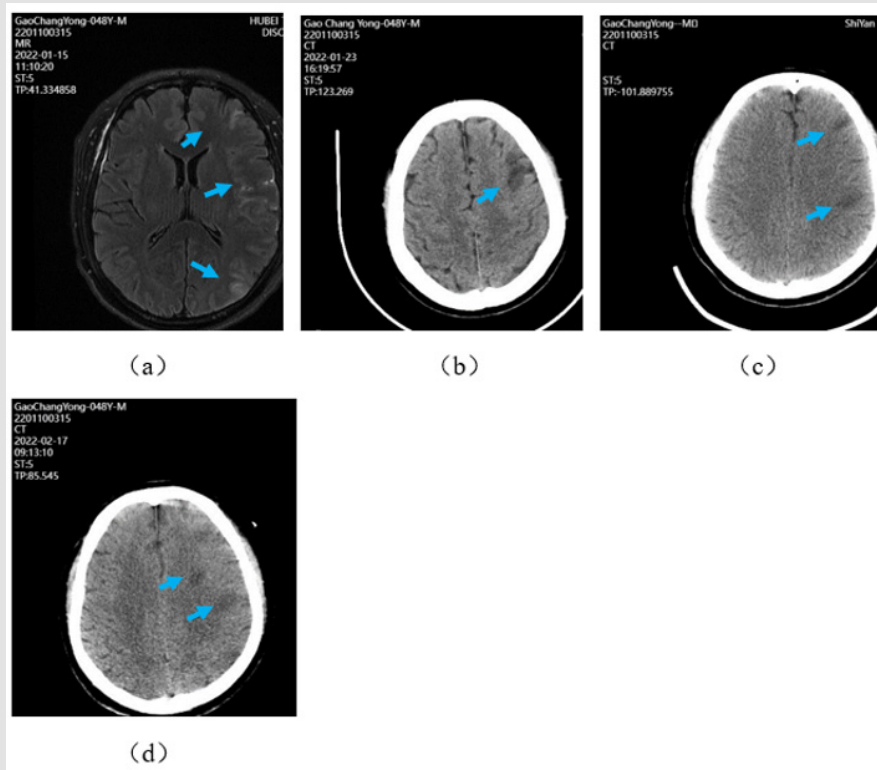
CT and MRI of brain.
